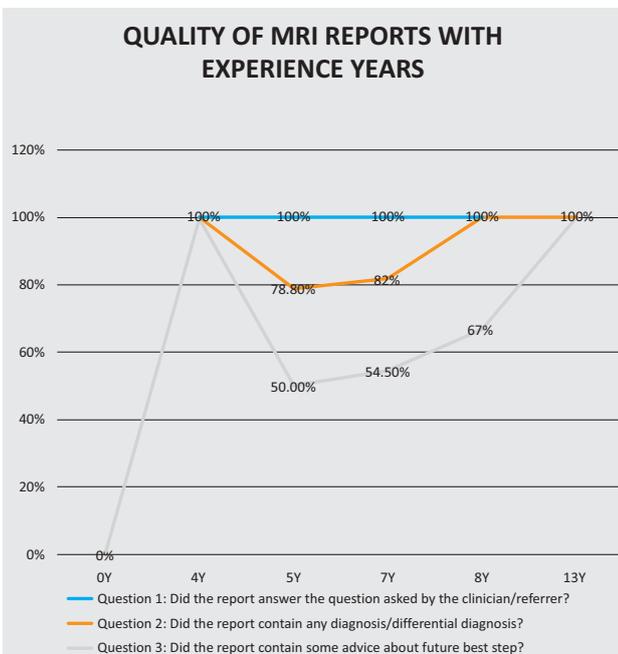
Showing relationship of MRI radiology reporting standards with experience years of reporting radiologist.
